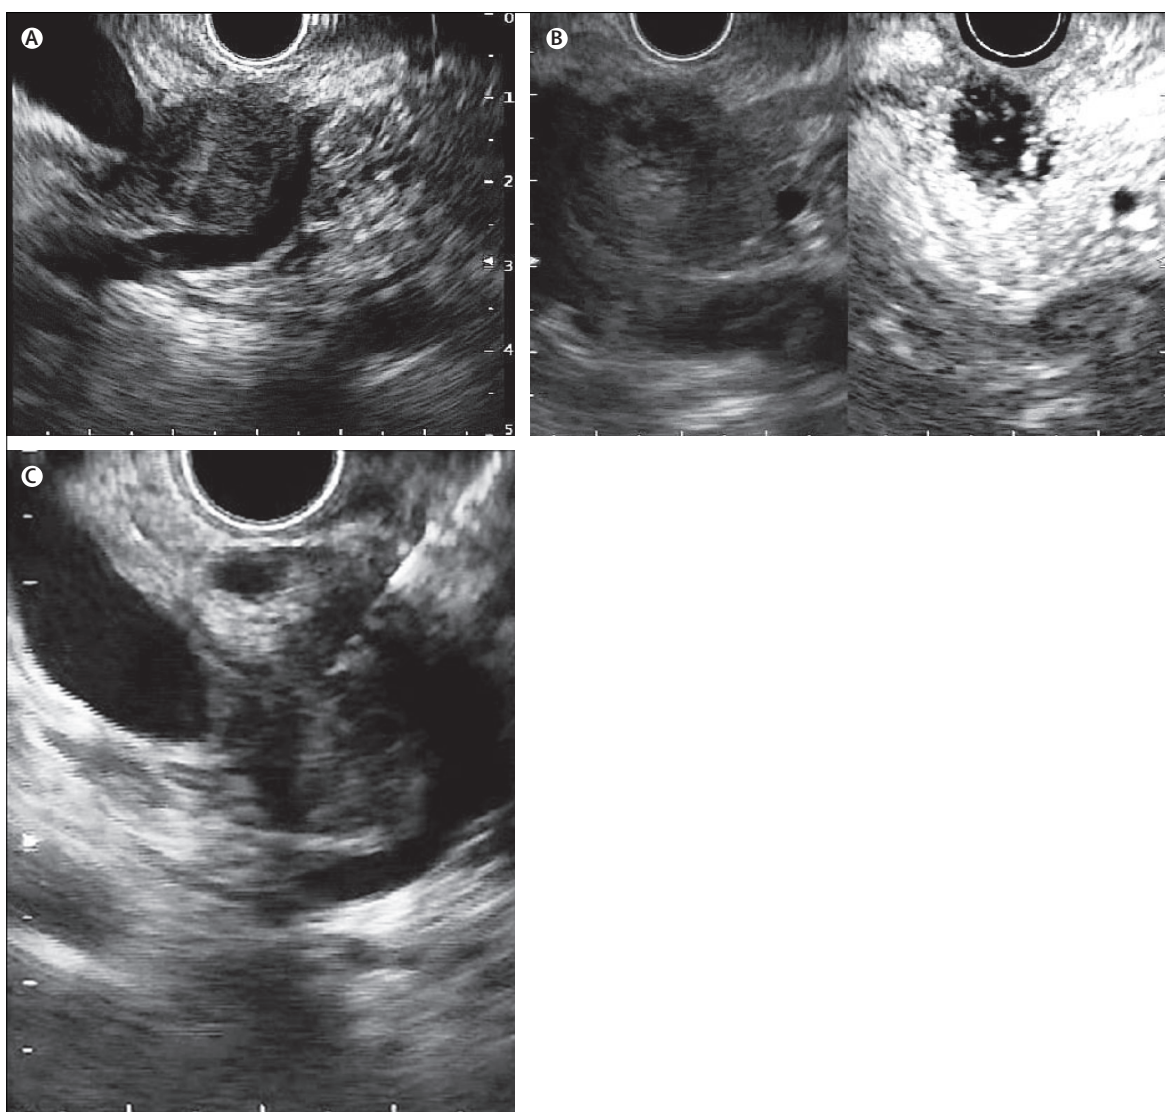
Endoscopic ultrasonography in pancreatic cancer
